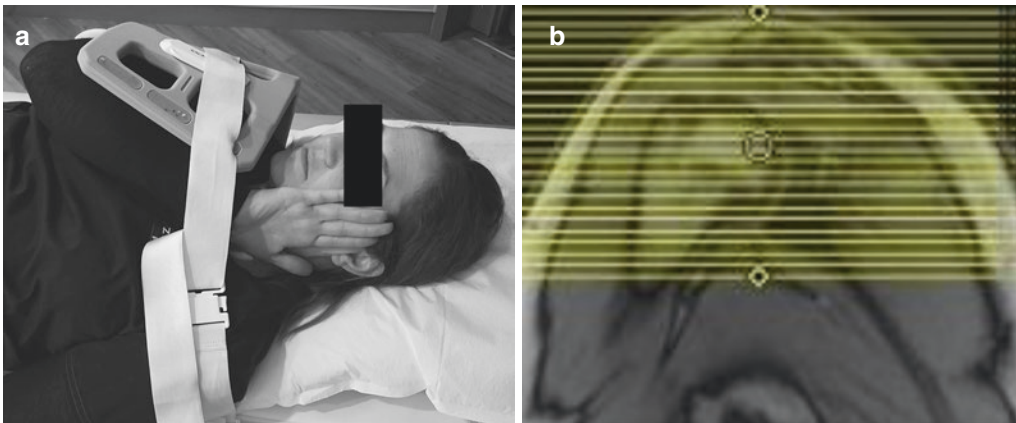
FADIR position.* FADIR MR images are prescribed from the coronal localizer to produce axial images
